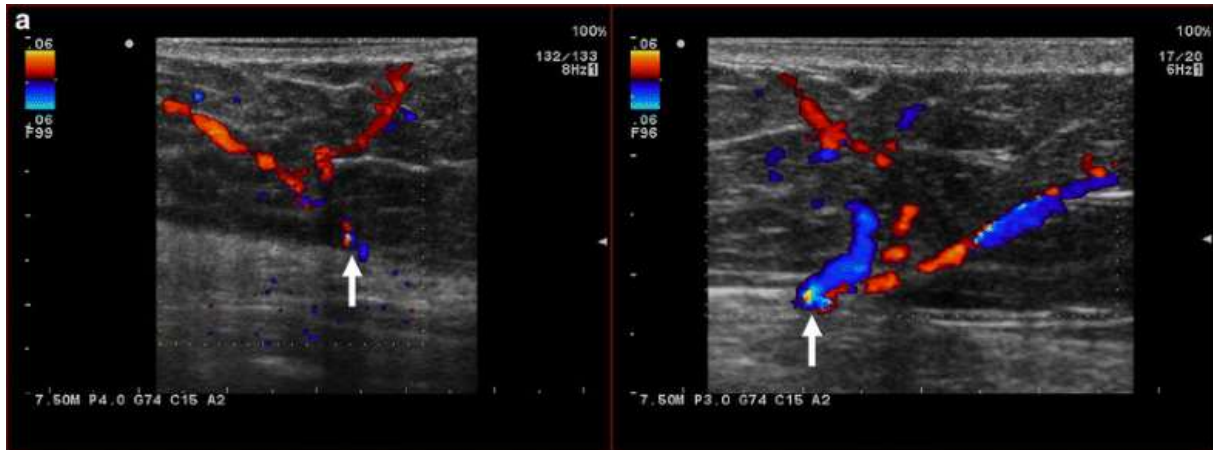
Colour Doppler image of the subcutaneous vessels in preoperative mapping of abdominal flap perforators. The colours represent blood flow in two different directions within an artery (red) and commitant veins(blue), respectively. Colour Doppler imaging can thus provide information on both the anatomical location and the function of subcutaneous vessels. Reprinted with permission from Aubry S et al. Preoperative imaging in the planning of deep inferior epigastric artery flap surgery. Springer Nature. Skeletal Radiology. 2012.
